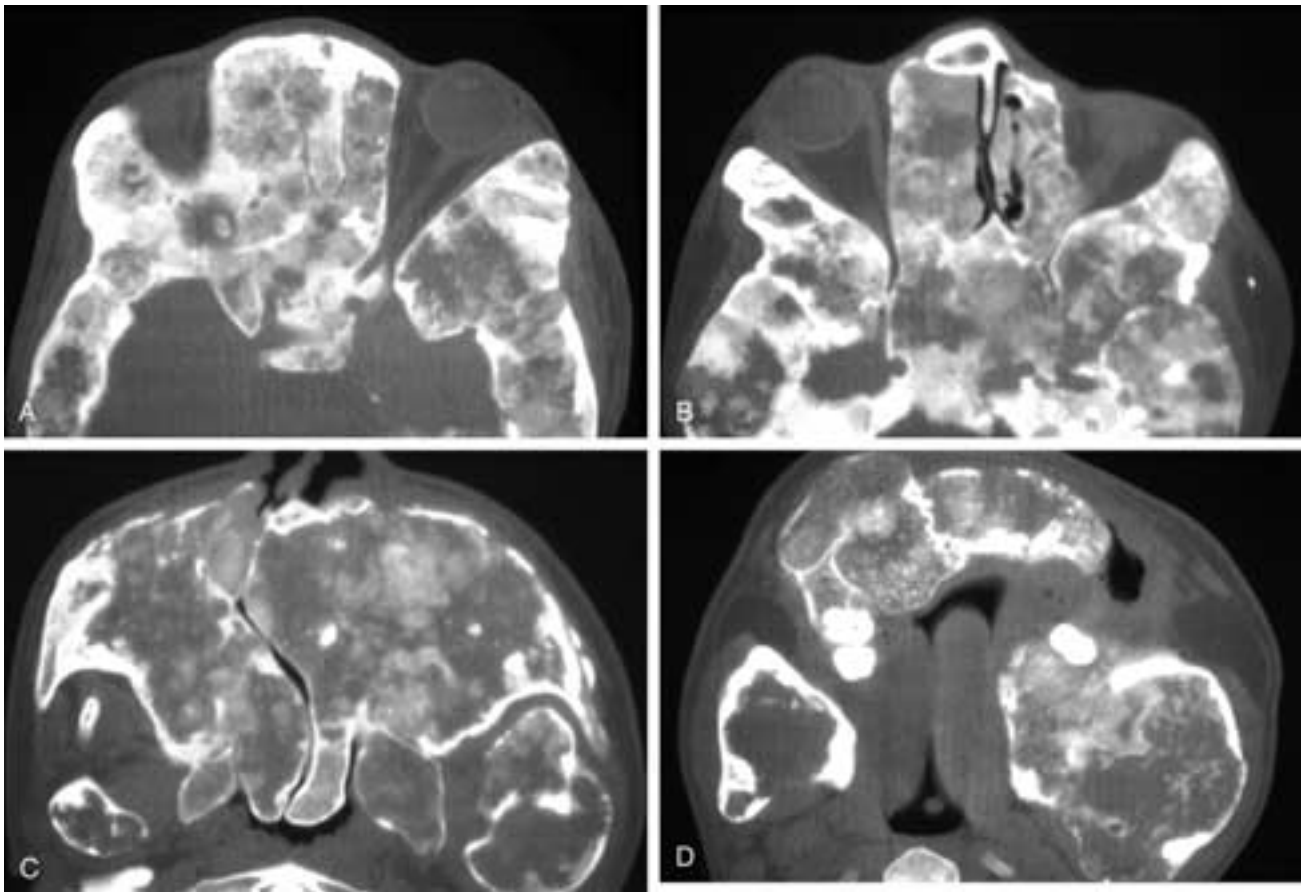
Axial serial CT scans (A through D) through the facial region show that all of the facial and skull base bones are greatly expanded, with intact cortices. Their medullary spaces are filled with ossified and nonossified regions. The skull base foramina, orbital apices, and paranasal sinuses are all obliterated. The mandible is also affected. This patient had fibrous dysplasia.
